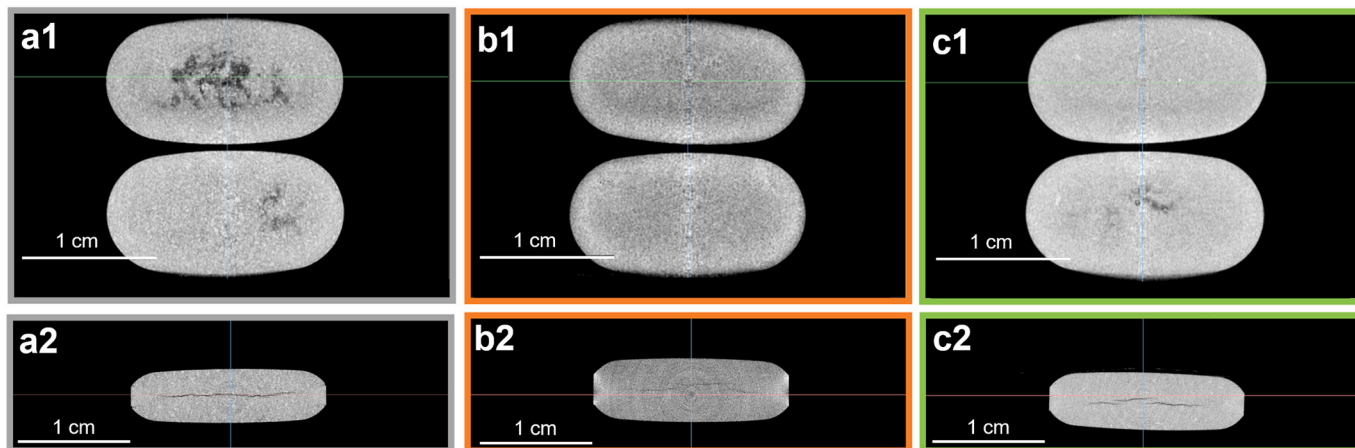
X-ray μ CT images ((1) radial; (2) axial cross section) of ASD tablets: (a) HME; (b) SD; (c) VDD.
